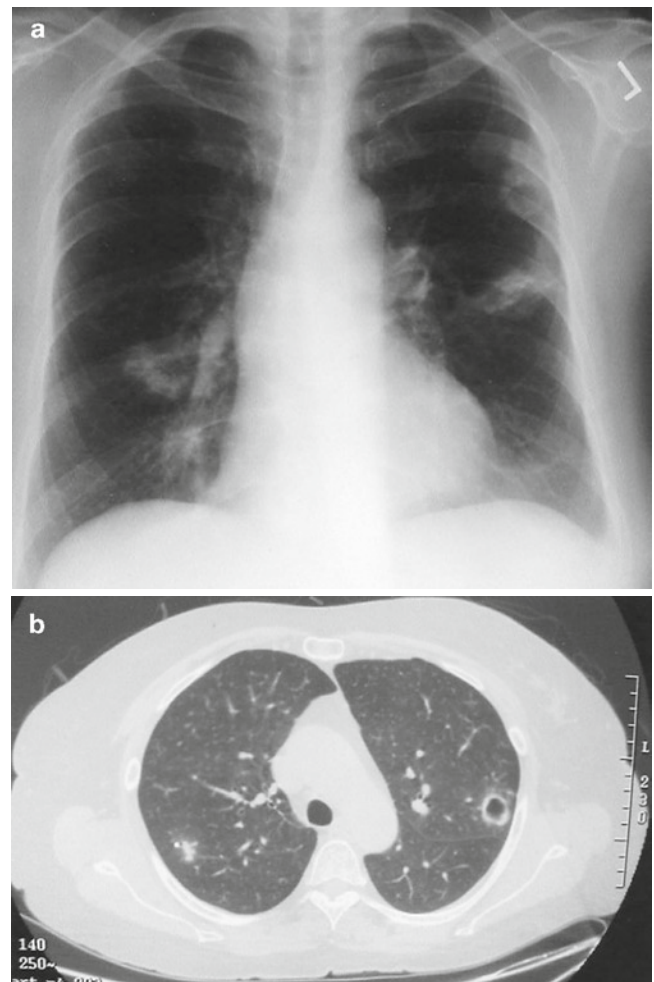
(a) Cryptococcal lung disease manifest as several irregular nodules. (b) Note cavitation of left lung nodule shown on CT scan
